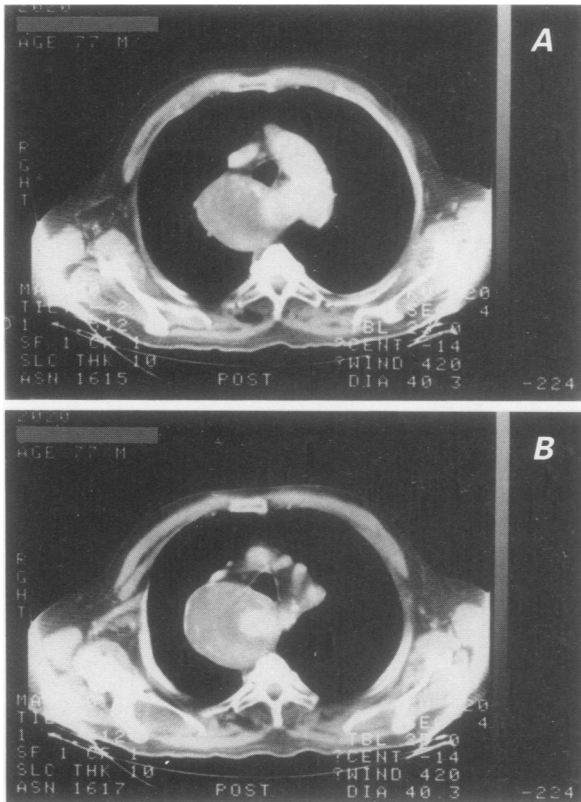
Computed tomographic (CT) scans in Case 2. A) Transverse view of the aortic arch showing a Kommerell diverticulum that turns into a large anomalous right subclavian artery aneurysm. B) Further enlargement of the anomalous right subclavian artery aneurysm (14 cm).
